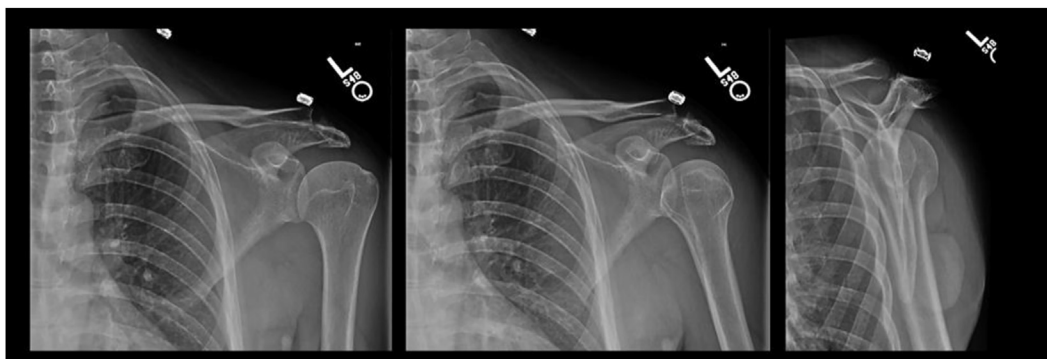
Three-view shoulder radiographs from initial injury demonstrating traumatic acromion fracture. MRI, magnetic resonance imaging.
